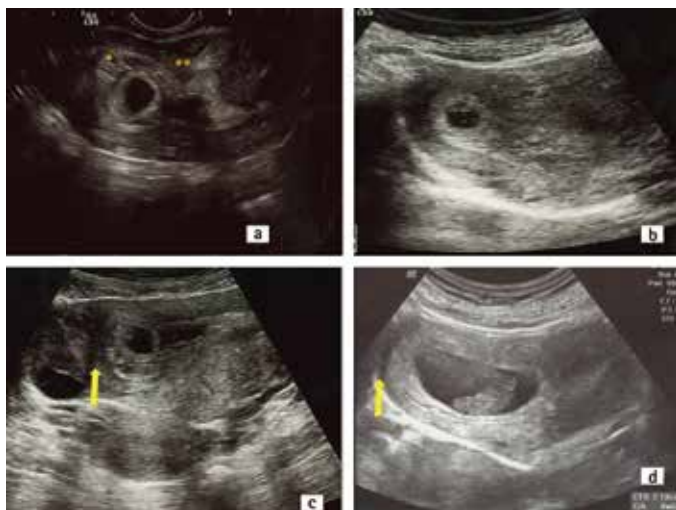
A) Transvaginal ultrasound view of the gestation sac at 6 weeks' gestation. The sac is covered by the endometrium (*) and continuous with the intracavitary endometrial lining (), B) Transabdominal ultrasound image of the angular pregnancy at 6 weeks' gestation. The gestational sac is located in the right lateral side of the uterus. The myometrium surrounding the sac is thick and the uterus is asymmetric C) The gestational sac growing towards the cavity at the 7th week, the ovary is seen lateral to the arrow. Note the thickness of the myometrium around the sac. D) Transabdominal ultrasound image of the angular pregnancy at 8+6 weeks' gestation. The asymmetric uterine enlargement is distinct
